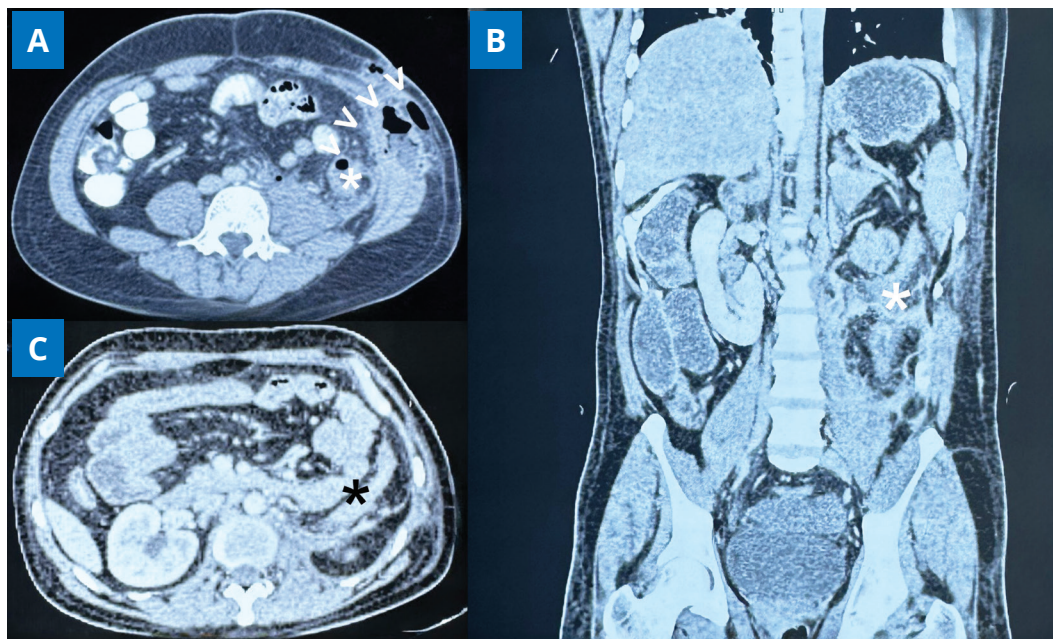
(A, B) Axial and coronal reconstruction sections depict retro colonic collection on the splenic flexure region (marked by *) with tracking into the adjacent subcutaneous space (marked by arrow heads); (C) post operative computed tomography (CECT) whole abdomen and pelvis (axial section) revealing no obvious collection in the renal fossa and retro colonic area (marked by *).
